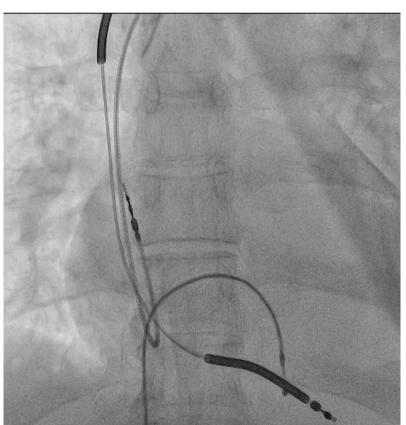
Fluoroscopy image of ICD leads before MRI scan
